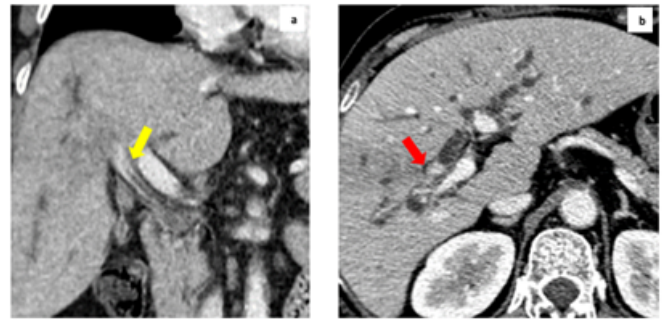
Type IIIa bismuth classification. Coronal section (a) portal venous phase CT showing enhancing periductal infiltrating type of cholangiocarcinoma in the common hepatic duct extending up to the primary confluence (yellow arrow). Axial section (b) portal venous phase CT of the same patient shows extension of tumour beyond the primary confluence into right hepatic duct (red arrow).
